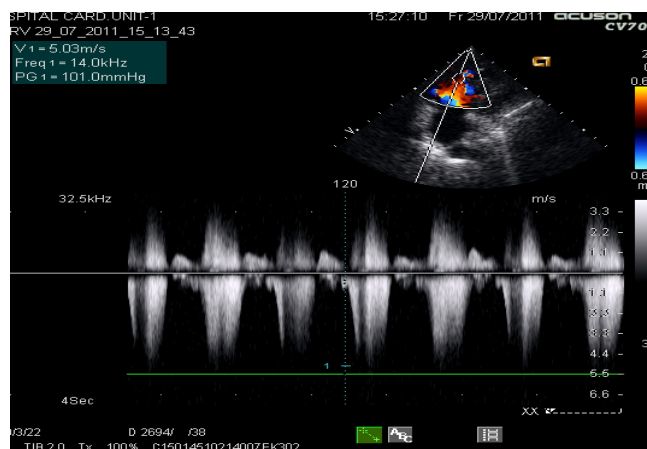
2 D Color Doppler showing restrictive left to right flow across the anomalous muscle band, with a peak systolic Doppler gradient of 100 mm Hg across the muscle band
